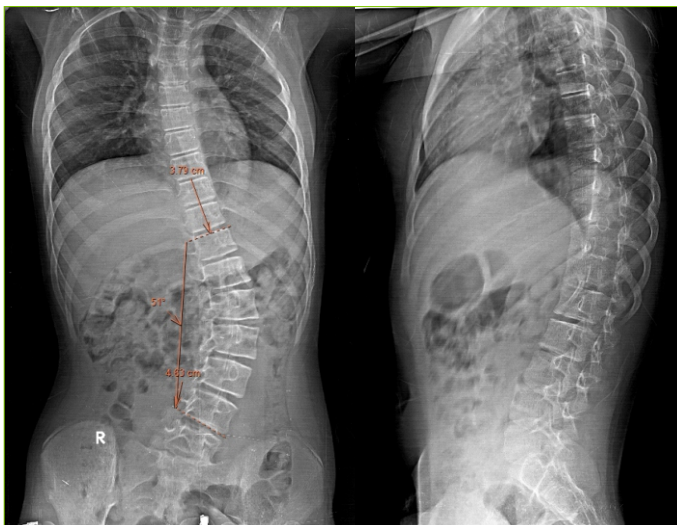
Traction Xray demonstrating partial correction of the curve.
